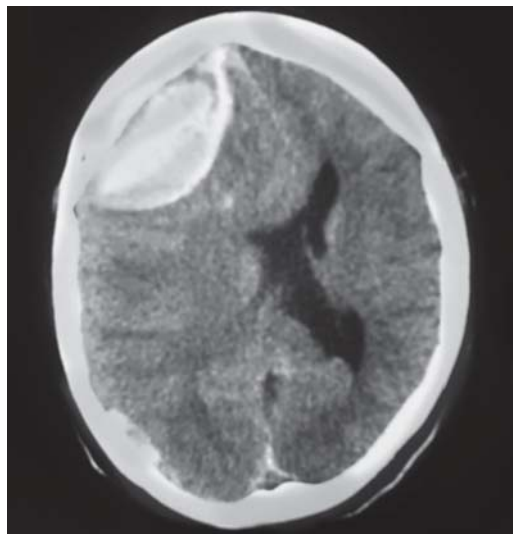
CT scan showing epidural hematoma
